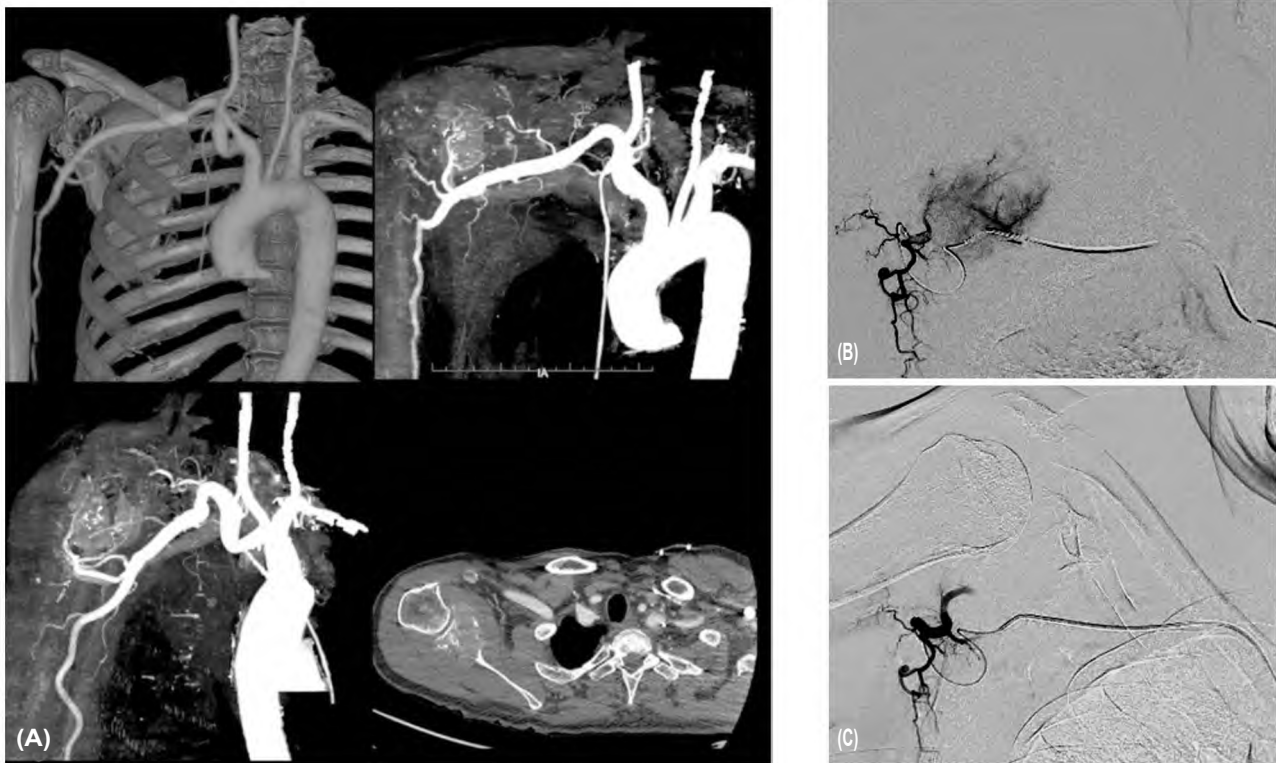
Male patient 62 years old with a well-defined destructive bony lesion seen at the right glenoid with extensive large extra-osseous soft tissue component. (A): CT angiography of the right upper limb revealed the previously described pathologically proven plasmacytoma. (B): Pre-embolization run (DSA) after super-selective catheterization of the main feeding artery using merit microcatheter revealed significant tumor blush. (C): Post-embolization run (DSA) after super-selective catheterization of the main feeding artery using merit microcatheter revealed no significant tumor blush.
